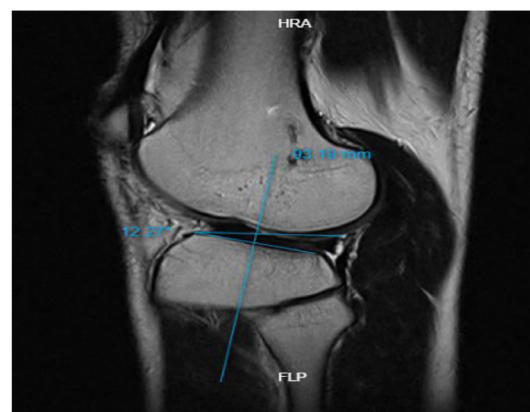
Measurement of tibial slope on sagittal MRI.
